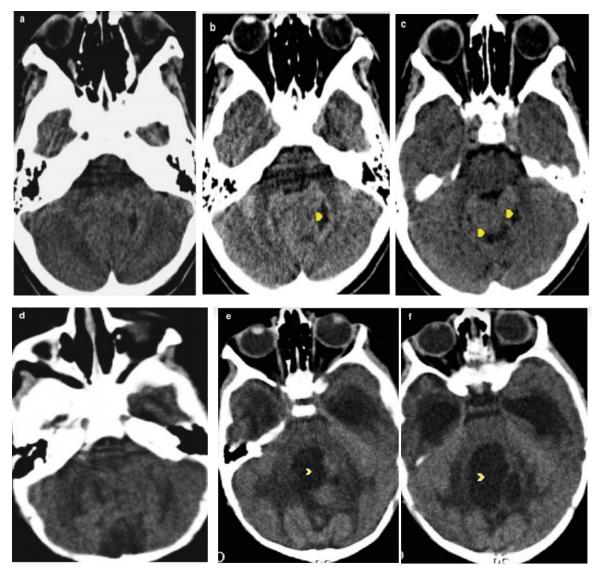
Variability of medulloblastoma on CT images:
